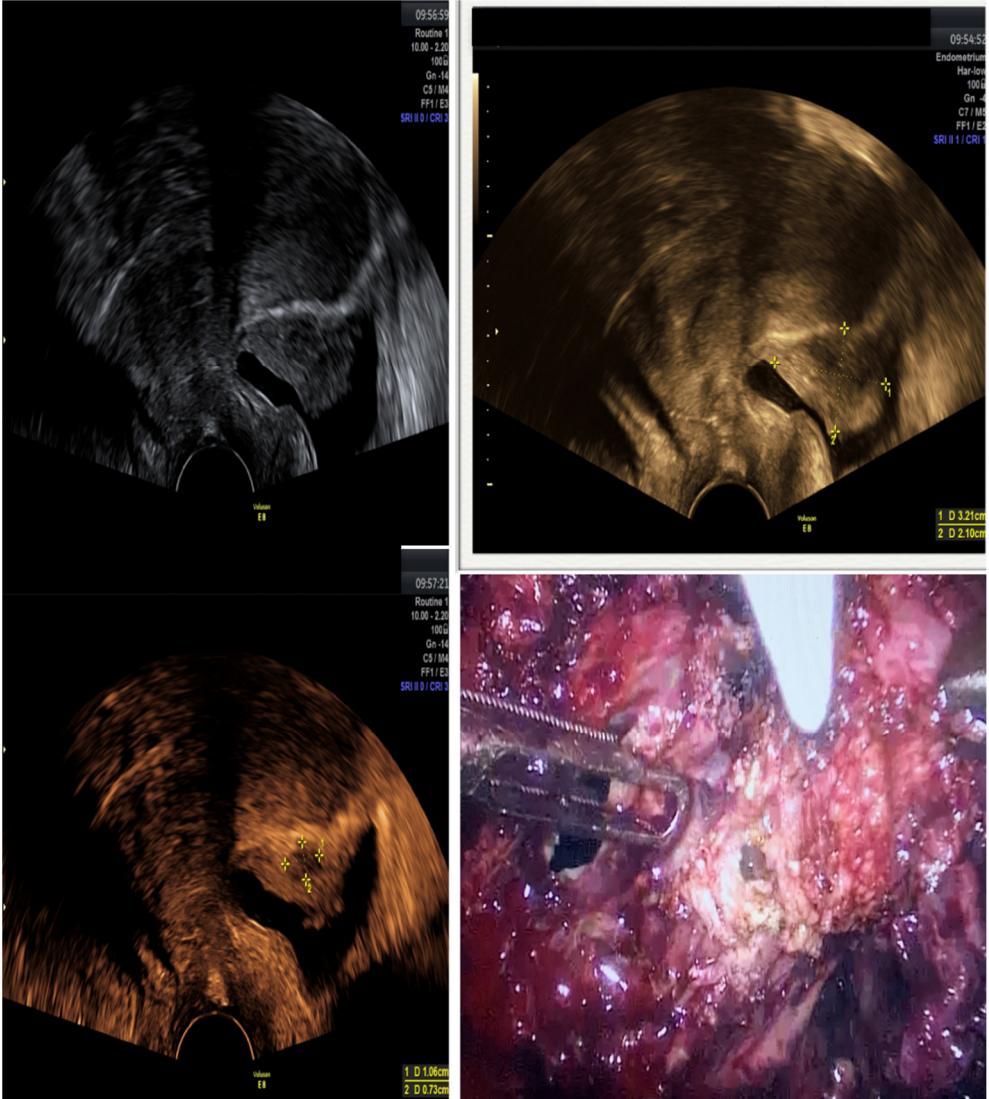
Bladder endometrioma visible on ultrasound
